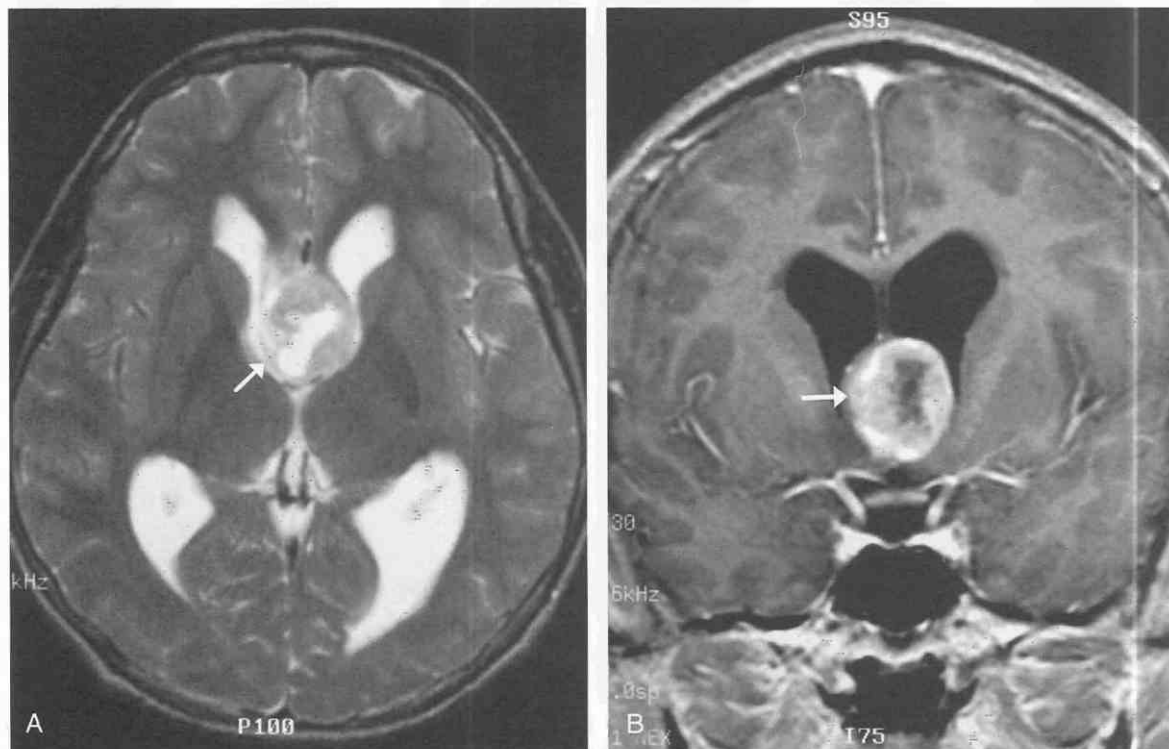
Glioblastoma multiforme involving the septum pellucidum. *A*, Axial T2-weighted MR image through the inferior aspect of the frontal horns of the lateral ventricles. An ovoid heterogeneously hyperintense mass (arrow) arising from the inferior aspect of the septum pellucidum indents and partially occludes the frontal horns bilaterally. Note the irregularly marginated intratumoral marked hyperintensity suggesting central necrosis. *B*, Following intravenous administration of gadolinium, a coronal T1-weighted image demonstrates intense contrast enhancement (arrow) of the thick peripheral rind with nonenhancement of the central cavity.
